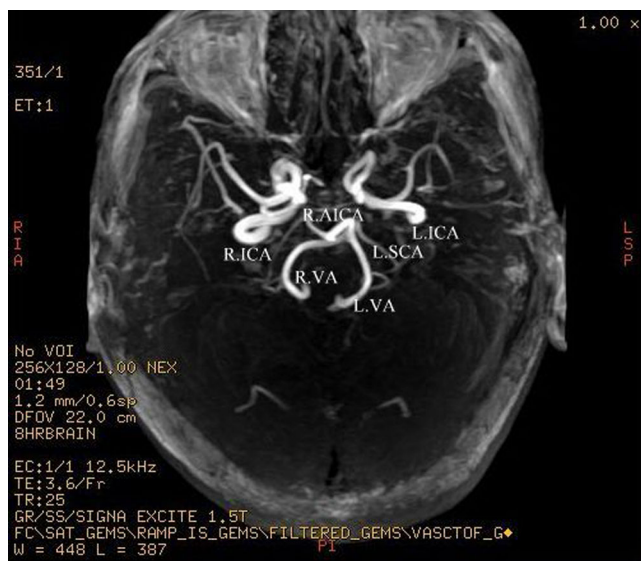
Magnetic resonance imaging findings. Three-dimensional time-of-flight magnetic resonance imaging delineated a tortuous vertebrobasilar artery (VBA) loop in the cerebellopontine area in all the cases. V: trigeminal nerve; VII: facial nerve; IX: glossopharyngeal nerve. R.AICA: right anterior inferior cerebellar artery; L.ICA: left internal carotid artery; R.ICA: left internal carotid artery; L.SCA: superior cerebellar artery; L.VA: left vertebral artery; R.VA: right vertebral artery
